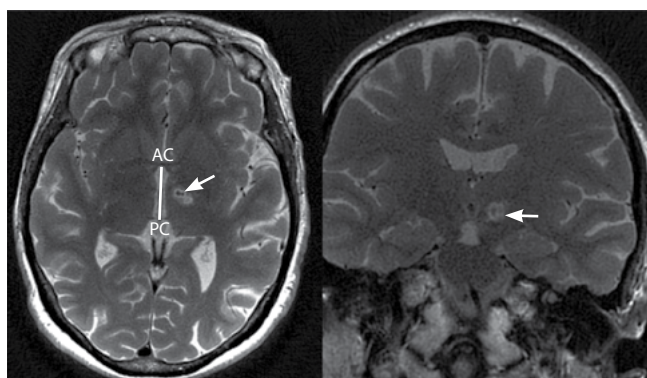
Axial and coronal MR images in 30 days after right PTT MRgFUS destruction. The arrow indicates the destruction focus.
